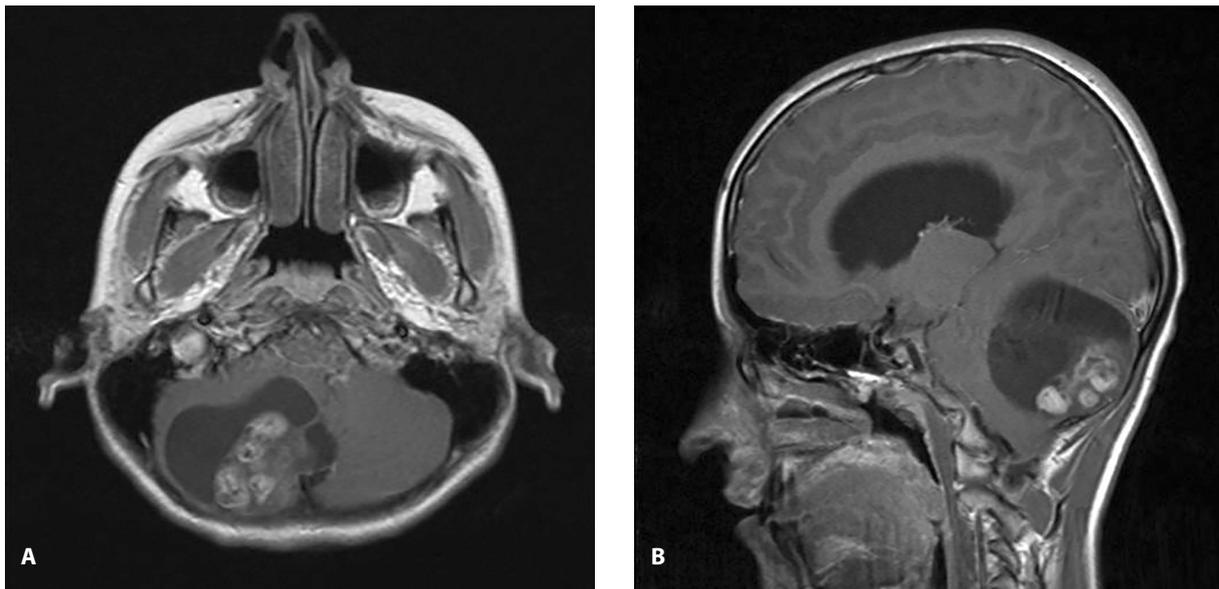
Axial (A) and sagittal (B) MRI showing irregularly shaped, mural and cystic, expansive and compressive lesion in the right cerebellar hemisphere with contrast uptake (pilocytic astrocytoma).
